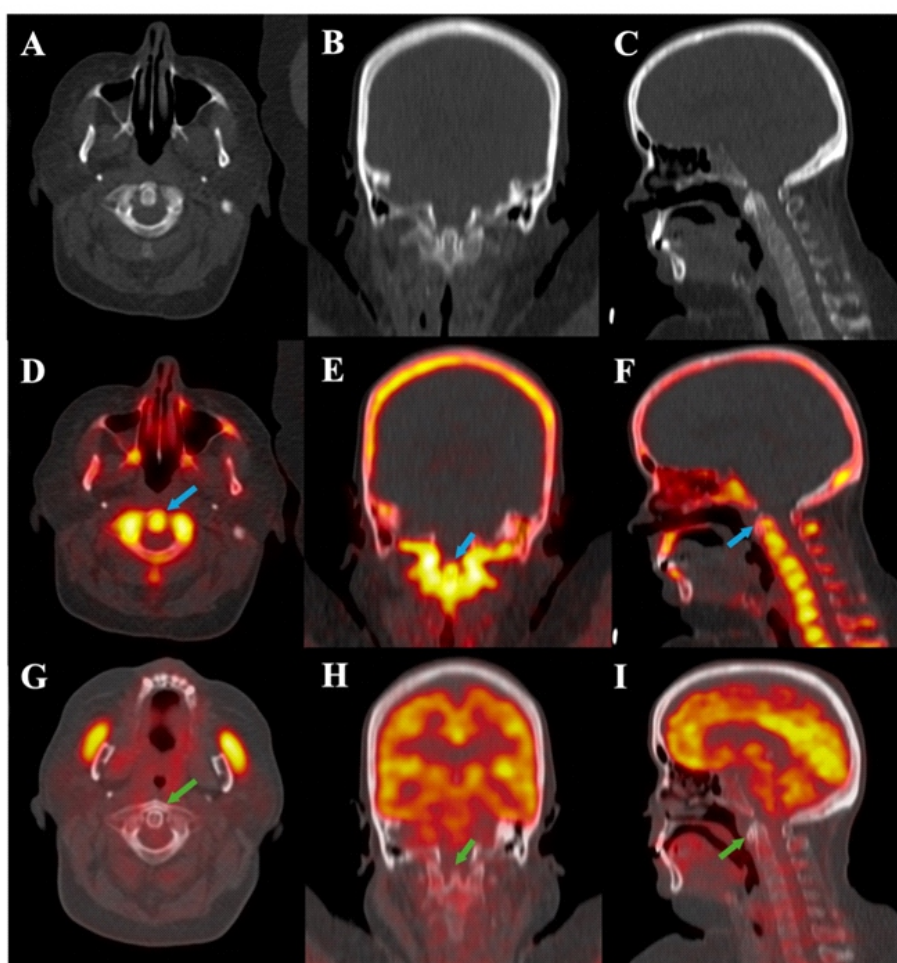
A 59-year-old white female with rheumatoid arthritis underwent dual-tracer PET/CT for systemic disease evaluation. Her medical history was significant for obesity, hypertension, and a smoking history. Serologically, she was anti-CCP positive with a normal ESR (13mm/hour) and elevated CRP (1.6mg/L). Clinically, she demonstrated high disease activity (DAS28-CRP of 5.4), a patient global assessment score of 75, and reduced hand grip strength. (A-C) Axial, coronal, and sagittal CT images demonstrate preserved alignment of the atlantoaxial joint without gross structural abnormality. (D-F) Fused ^{18}F -NaF PET/CT images show focal periarticular uptake at the atlantoaxial articulation (SUVmean 6.56, SUVmax 11.99) (blue arrows). (G-I) Fused ^{18}F -FDG PET/CT images show minimal uptake in the same region (SUVmean 0.75, SUVmax 0.89) (green arrows), underscoring discordant osteogenic and inflammatory processes.
